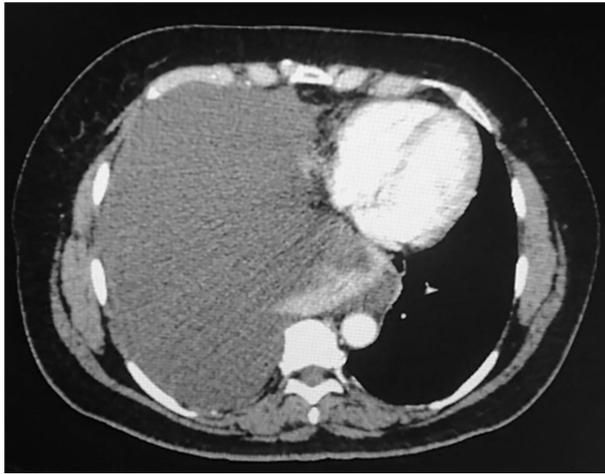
Chest CT scan showing right pleural effusion.
